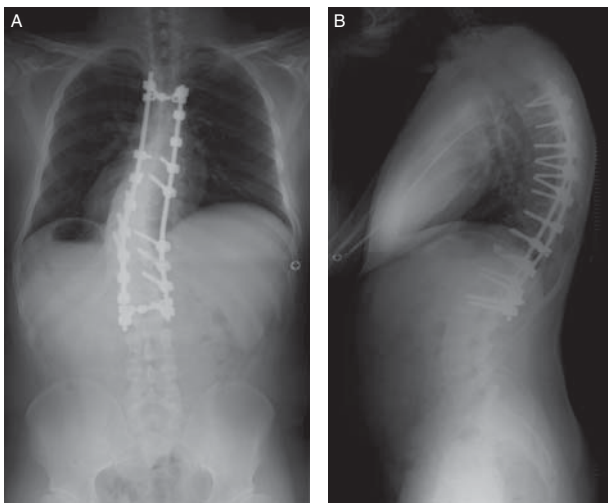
Postoperative antero-posterior (A) and lateral (B) radiographs that were conducted 2 years after the surgery show the corrected coronal curve (86° to 34° with a correction rate of 60%) and the corrected kyphosis (67° to 50°).
